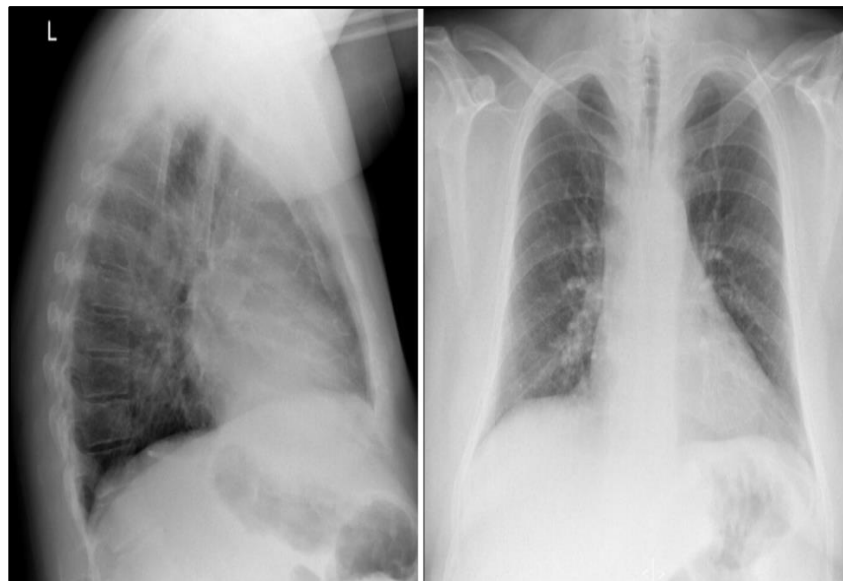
Chest X-Ray Ordered by ED Physician
